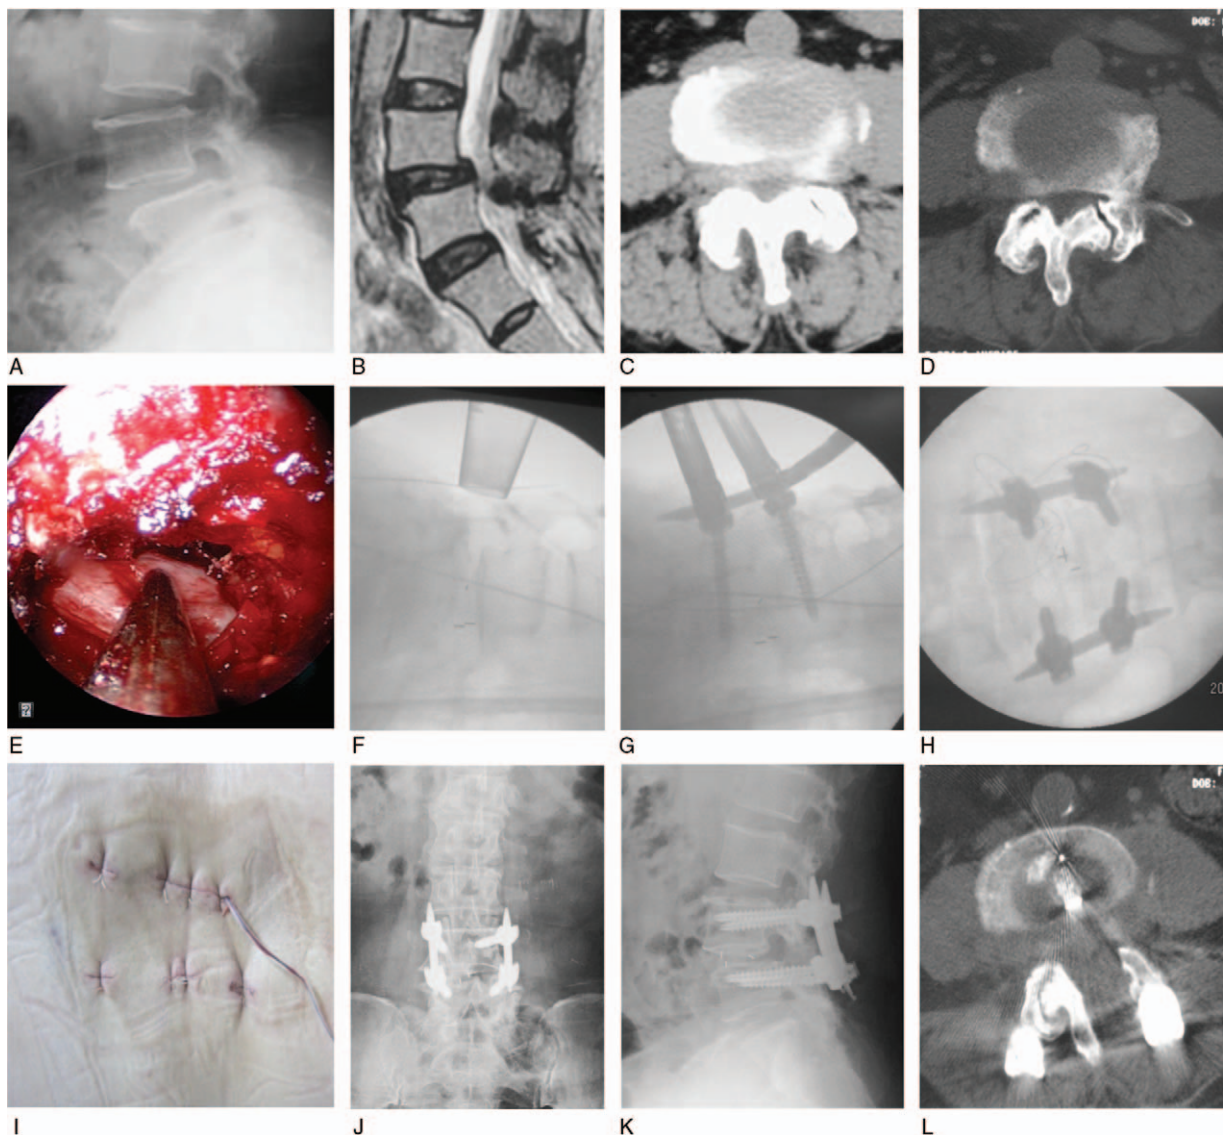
A 64-year-old woman with L4,5 spinal stenosis combined with spondylolisthesis was treated with bilateral decompression via left fenestration and intervertebral fusion using the MMED technique. The symptoms disappeared after the operation, and the clinical result was excellent. (A) Preoperative x-ray showing L4/5 spondylolisthesis. (B) Preoperative MRI showing L4,5 disc protrusion combined with spondylolisthesis. (C and D) Preoperative CT scans showing L4,5 bilateral spinal stenosis. (E) Intraoperative endoscopic vision showing the contralateral nerve root after undermined contralateral decompression. (F) Intraoperative radiological image showing bone grafting and intervertebral fusion. (G) Intraoperative radiological image showing the placement of the connecting rod after the insertion of percutaneous screws. (H) Anteroposterior x-ray showing good positioning of the connecting rod. (I) There was one 2.5 cm incision for decompression (a negative pressure drainage was placed), 2 contralateral incisions for the placement of pedicle screws, and 2 incisions for the puncture of the connecting rods. (J and K) Postoperative anteroposterior and lateral x-rays showing good position of instruments and improved spondylolisthesis. (L) Postoperative CT scans revealing bilateral decompression, enlargement of the canal, intact contralateral structure and good position of the cage. CT=computed tomography, MMED=mobile microendoscopic discectomy, MRI=magnetic resonance imaging.
